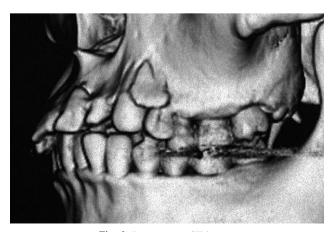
Pretreatment CT image.
